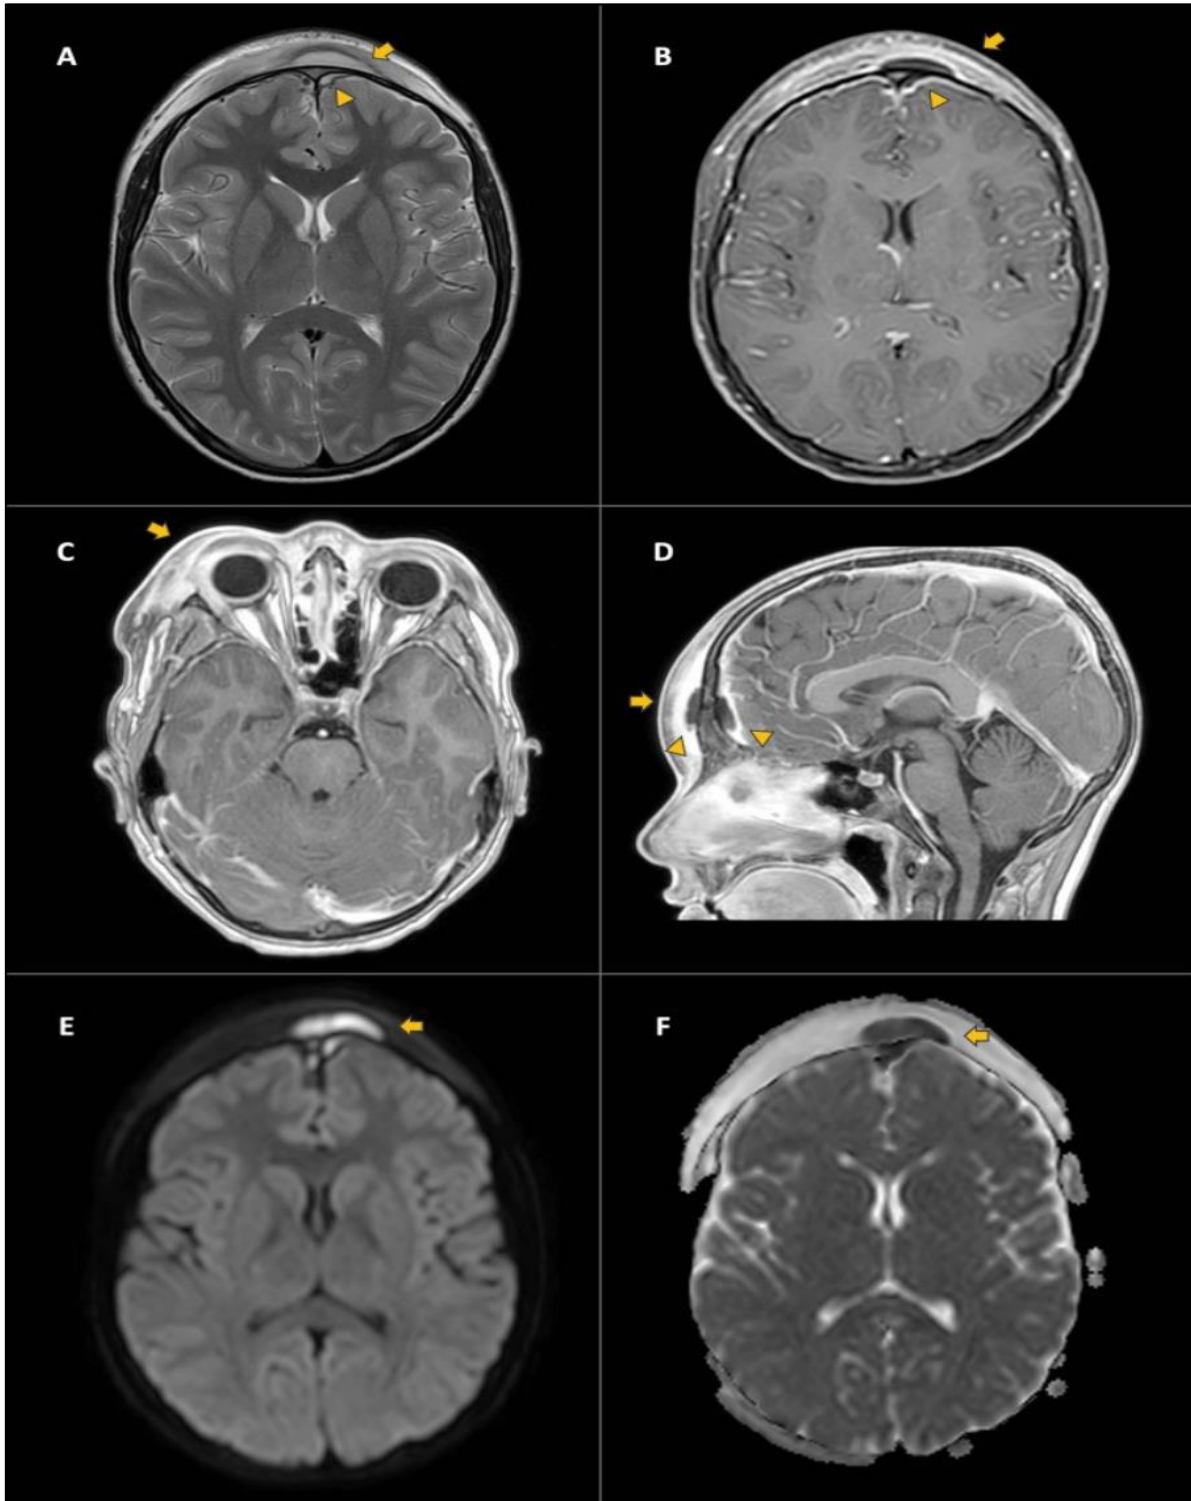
Contrast-Enhanced MRI of the Skull.
